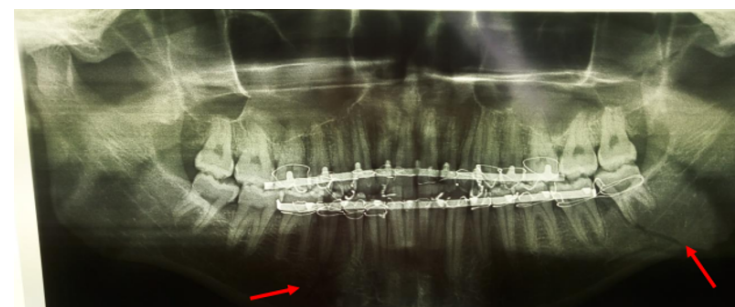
D14 panoramic control radiograph of a 23year old patient
